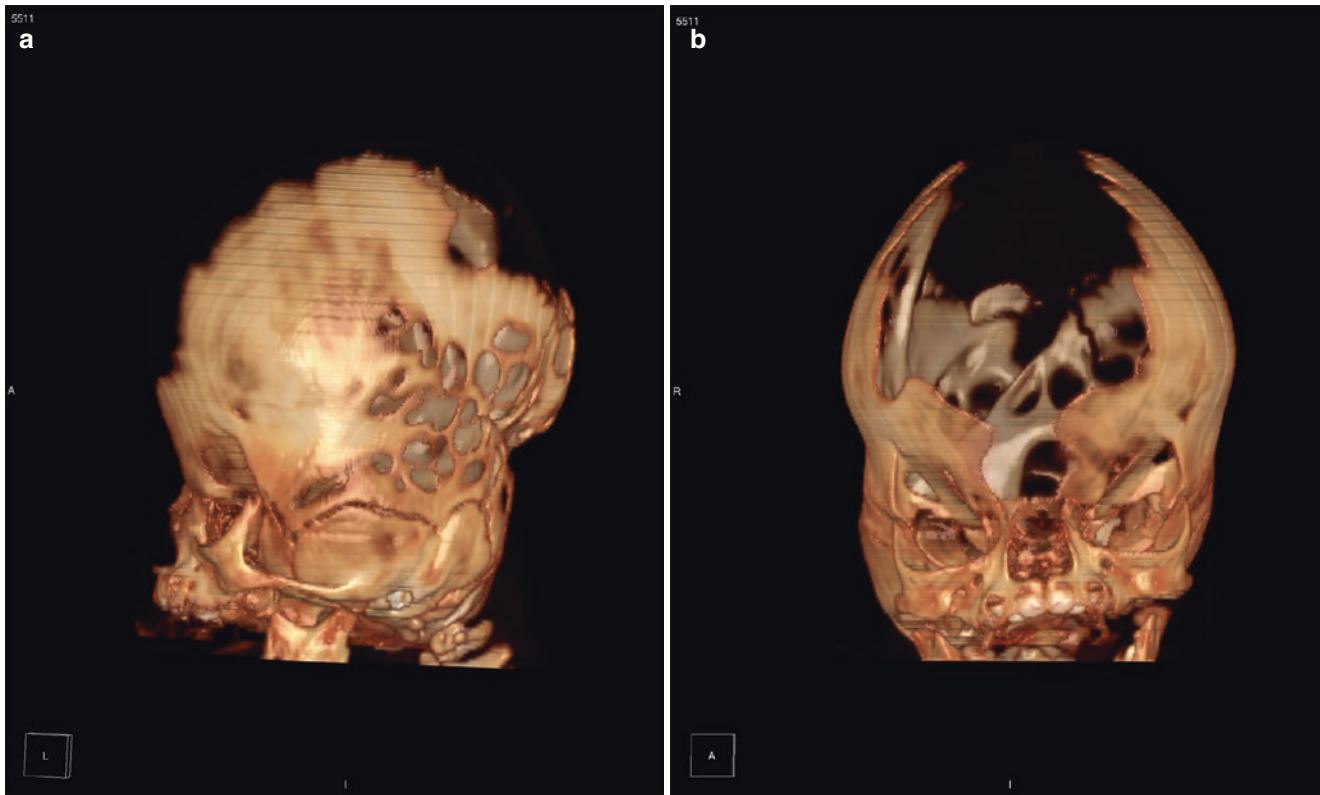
Lateral (a) and frontal (b) 3D reformatted CT images of head demonstrating bulging and marked thinning of the calvarium in a child with cloverleaf skull
